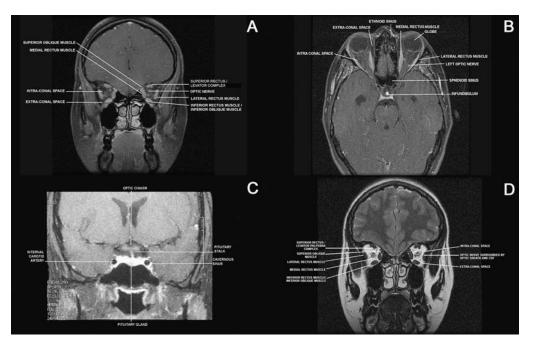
Fat-saturated postgadolinium images: (A) coronal image through posterior orbit, (B) axial image through optic nerve, and (C) coronal T2-weighted image through the optic chiasm. (D) Direct coronal T2weighted image at midorbit.
